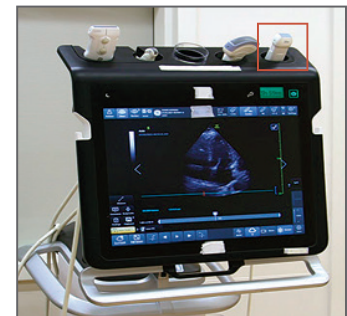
Ultrasound Machine with Phased-Array Probe.
